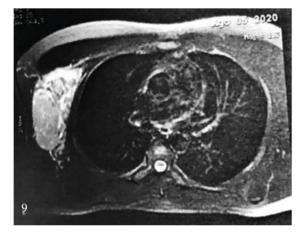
MRI scan showing a hyperintense, heterogeneous mass in the superolateral quadrant of the right breast.
